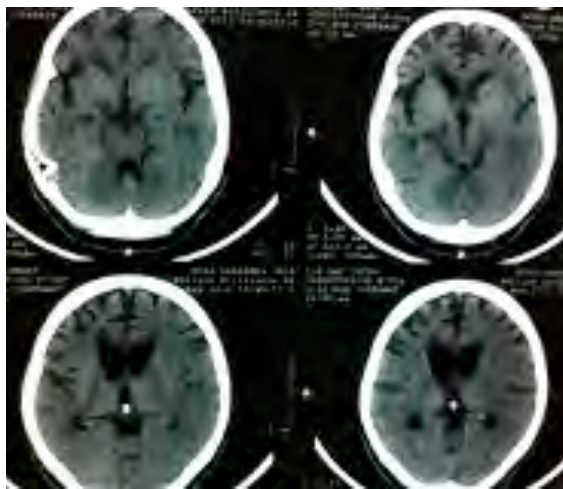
CT Brain Images of T August 2012 showing preferential temporoparietal atrophy
